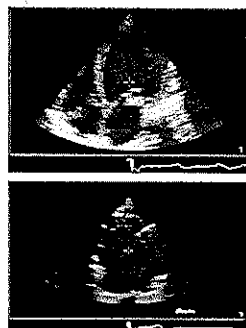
We use advanced techniques of doppler echocardiography to determine the diastolic function.
